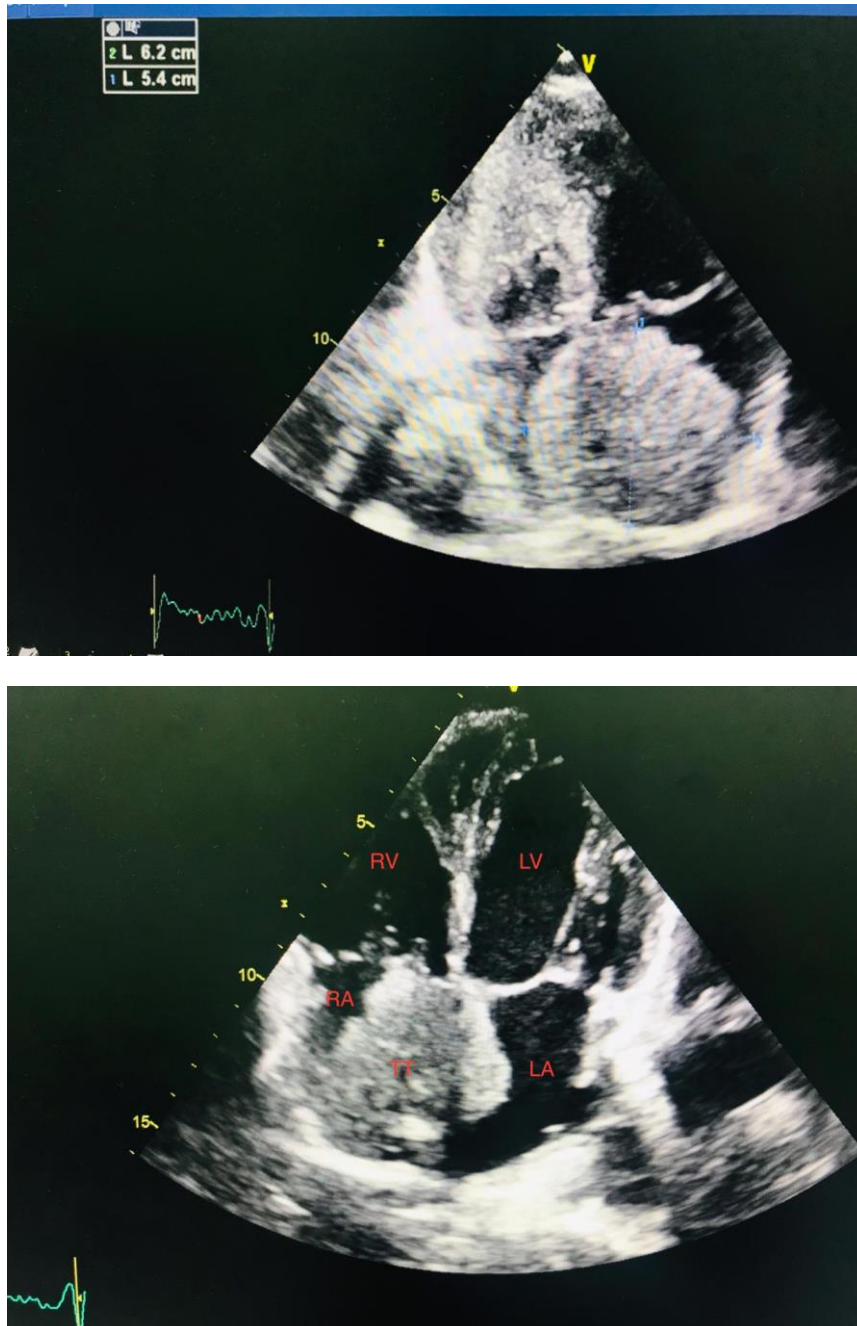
Trans-thoracic ultrasound in apical four chamber view objectifying a mass filling the OD of about 62 x 54 mm, pushing back the interatrial septum, without obstruction of the tricuspid flow and without impact on the right heart. RV : right ventricle, LV : left ventricle; LA : left atrium; RA : right atrium, TT : tumor thrombus.
